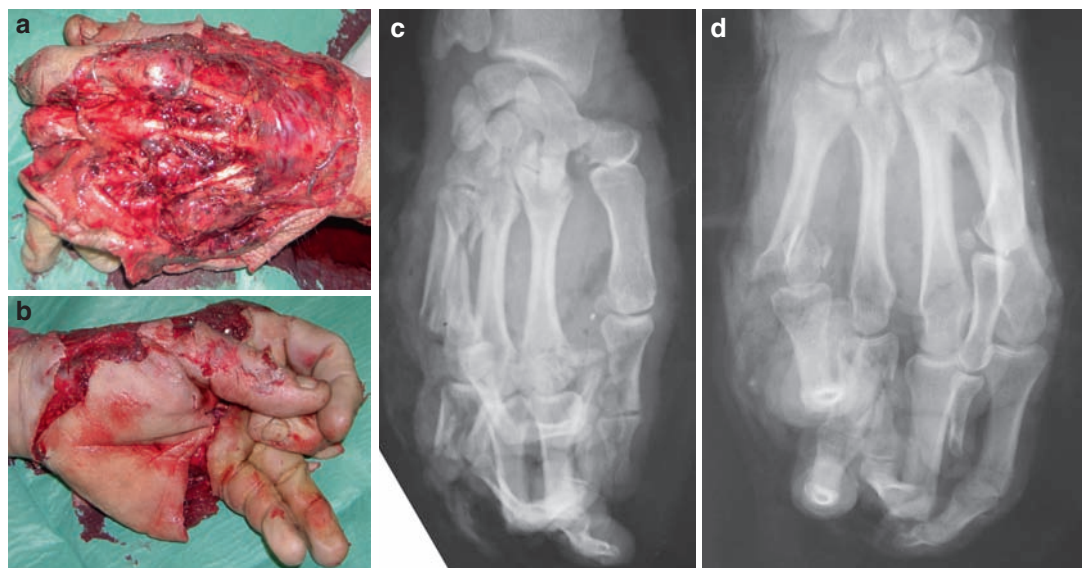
(a–d) Severe crush injury to the hand. Documentation by digital pictures and X-rays.
